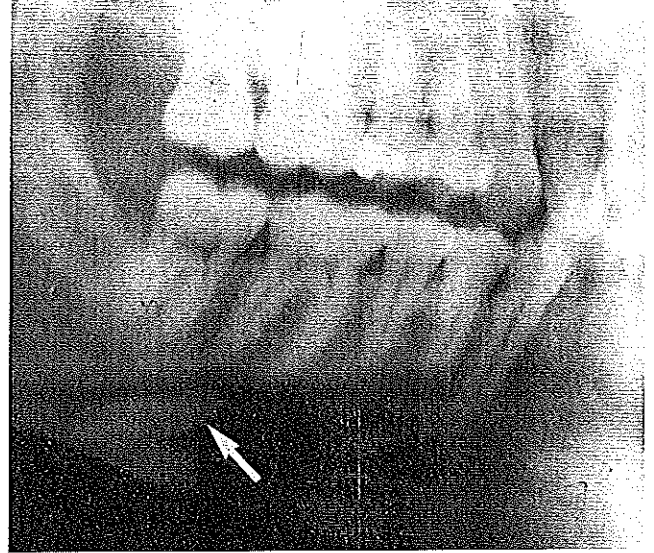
Lateral radiograph demonstrating calculus (arrow) in the hilum of the submandibular gland.
